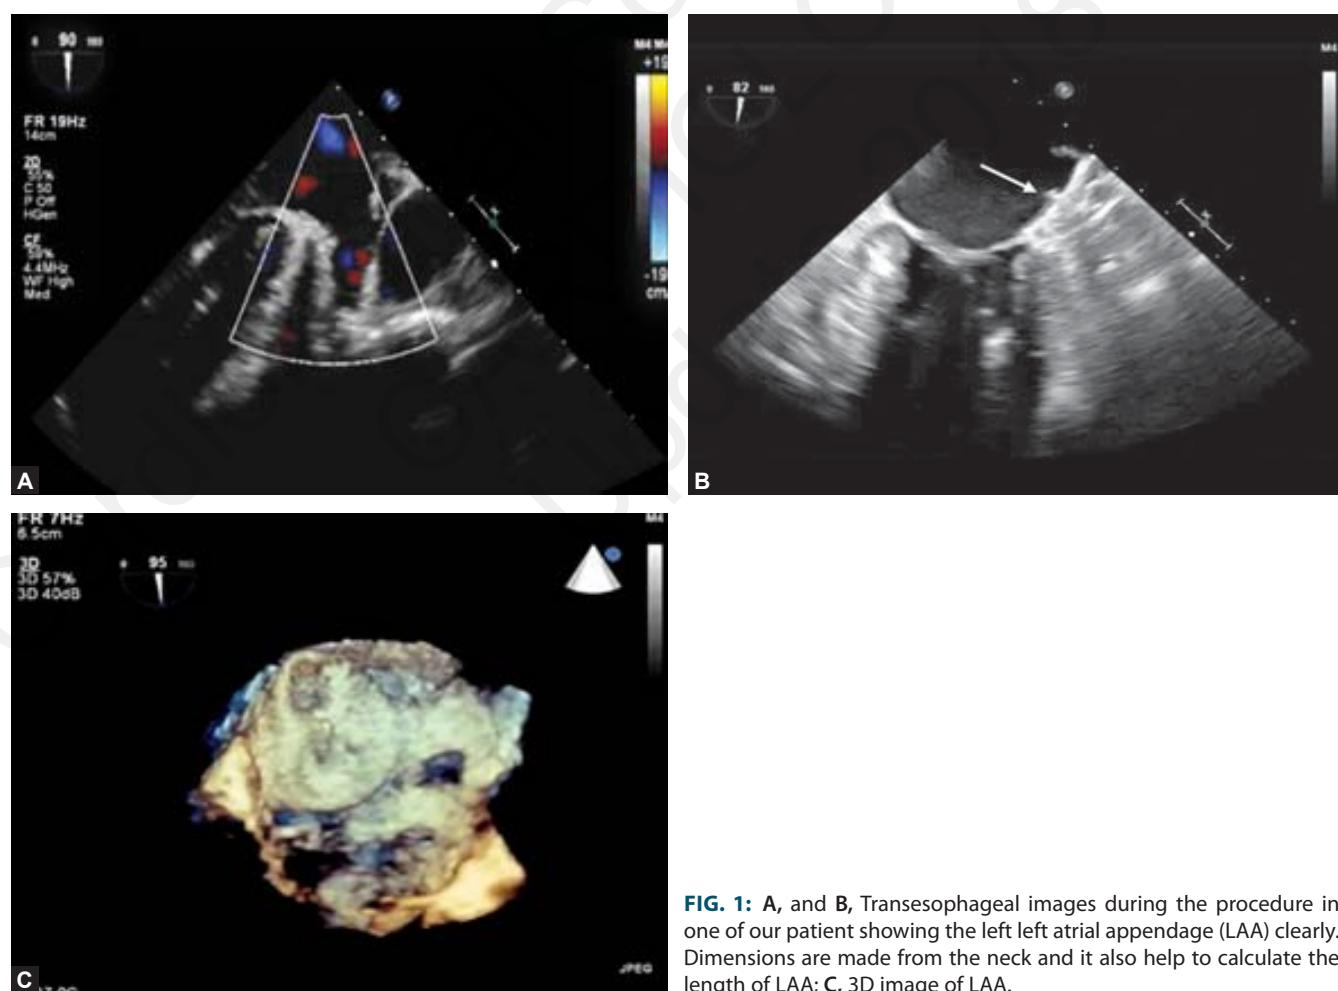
A, and B, Transesophageal images during the procedure in one of our patient showing the left left atrial appendage (LAA) clearly. Dimensions are made from the neck and it also help to calculate the length of LAA; C, 3D image of LAA.
